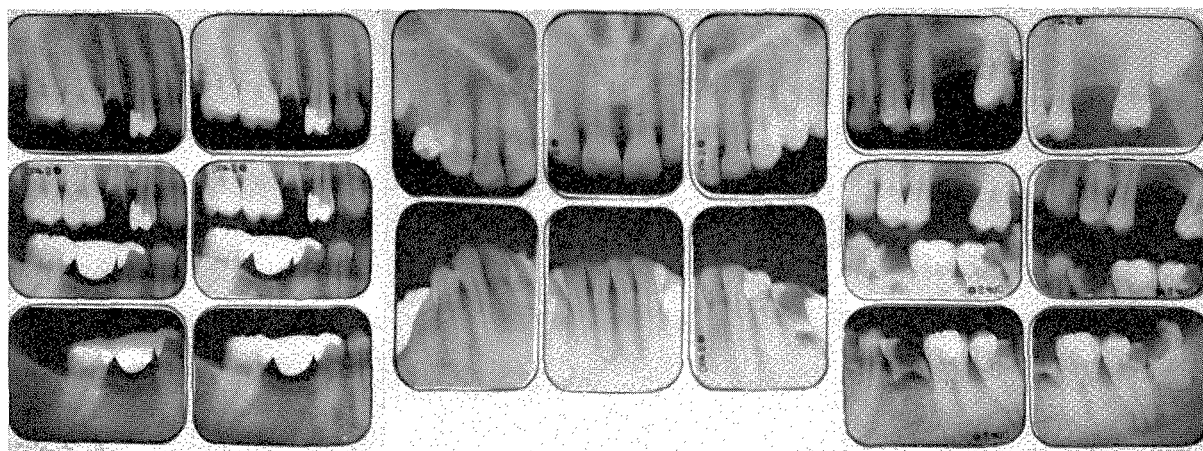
Roentgenograms of the teeth at the start. These were taken in April, 1959.
